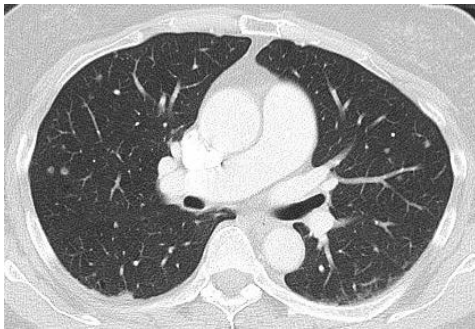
Computed tomography scan of the chest demonstrates multiple sub-centimetre pulmonary nodules in both lungs.
